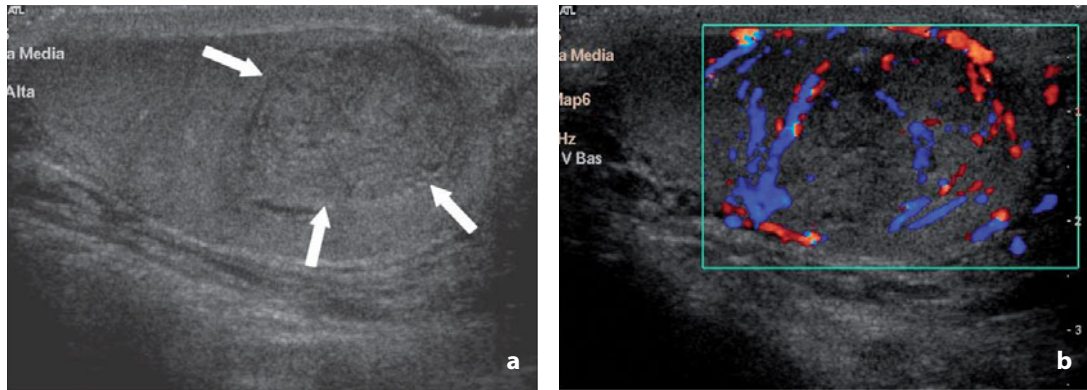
Focal orchitis. a In a clinical setting of inflammation a rounded intratesticular formation can be seen (*arrows*) with internal vasculature at color Doppler (b)
